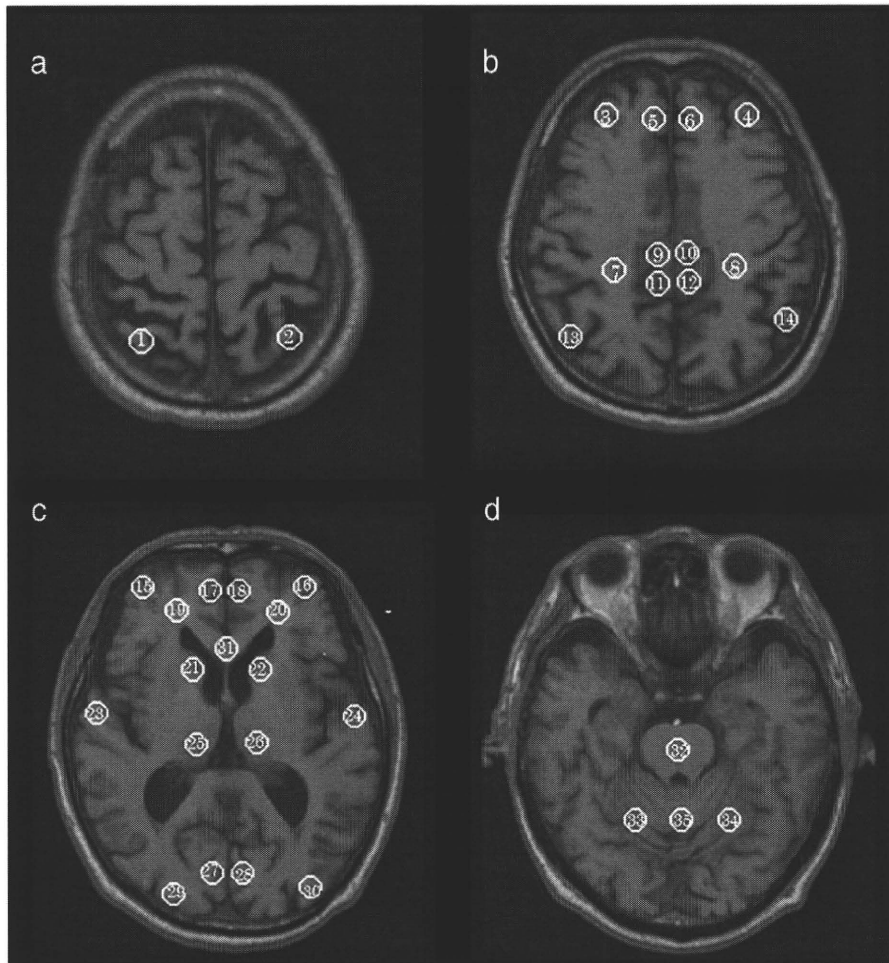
Brain templates displaying ROIs on axial MR images of a normal brain. Thirty-five regions of interest (ROIs), numbered from 1 to 35, are located in these four slices of MR images parallel to the AC-PC line. The 35 ROIs were lumped into 16 regions (Table 3) and quantitative rCBF was averaged for each region. (a) superior parietal lobe level; (b) posterior cingulate gyrus and precuneus level; (c) thalamus level; (d) pons level.
